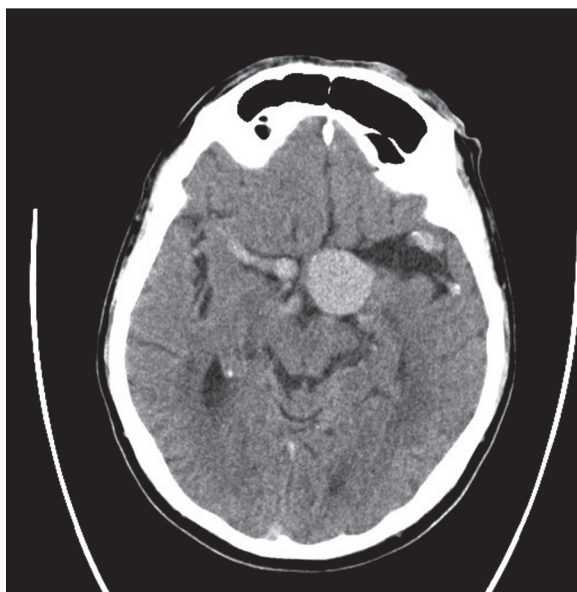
Non-enhanced CT scan (axial view) shows giant aneurysm of left internal carotid artery, aneurysm of right internal carotid artery, dilatation of middle cerebral arteries.
